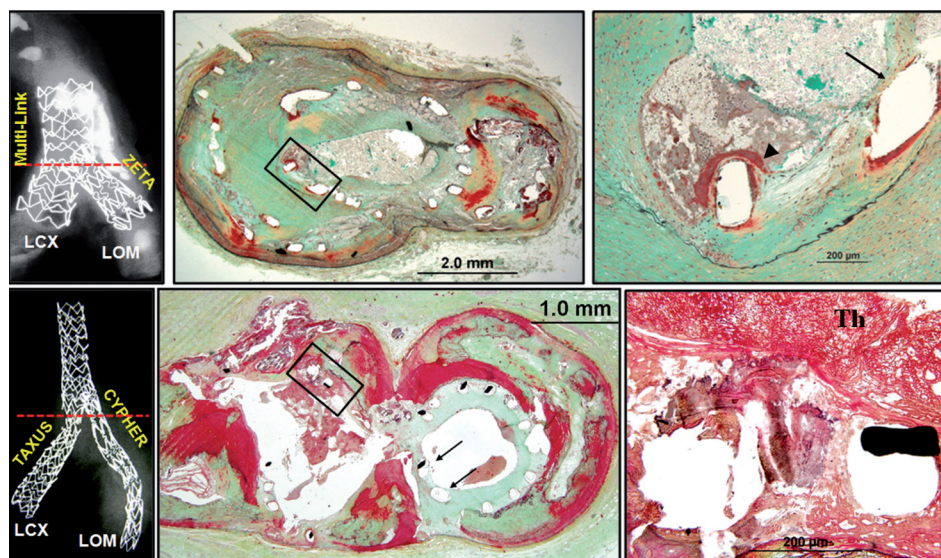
Examples of coronary bifurcations treated with BMS and DES. (Top row) A 77-year-old male with history of severe coronary artery disease received two bare metal stents (4x10mm Multi-Link and 3x9 mm Multi-Link ZETA) in the mid-left circumflex artery (LCX) and first left obtuse marginal branch (LOM). The patient died suddenly 1.5 years after stent implantation. Radiograph show moderate calcification of the coronary arteries. Stents struts show complete coverage except at the carina, where two stent struts are either covered by a thin layer of neointima (black arrow) or there is a platelet-rich surface thrombus (arrow head). (Bottom row) A 69-year-old female with history of hypertension, end-stage renal disease and severe coronary artery disease, she received two overlapping drug eluting stents (3.5x25 mm Taxus and 2.5x20 mm Cypher) in the left circumflex artery (LCX) and left obtuse marginal branch (LOM). The patient died suddenly six months after stent implantation. Stent fractures were observed in both the Cypher and Taxus stents. The stent struts show complete healing in the lateral walls in Cypher (LOM) with a thin layer of neointima in the lateral wall however in the carinal region (black arrow) there are two uncovered struts in Taxus (high magnification image) with overlying adherent thrombus (Th). (red dashed line indicates sampling region)
